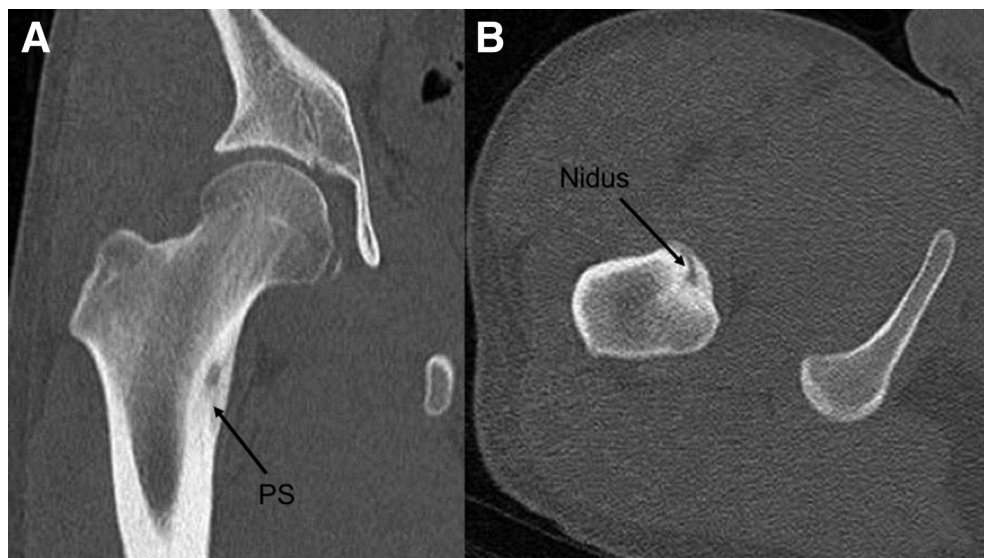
Computed tomography imaging of the reported case. Coronal (A) and axial (B) images showing an 8 mm × 7 mm × 5 mm lesion with a central osteolytic lesion (nidus) and perinidal sclerosis (PS) in just the anteromedial area of the lesser tuberosity of the right femur.
